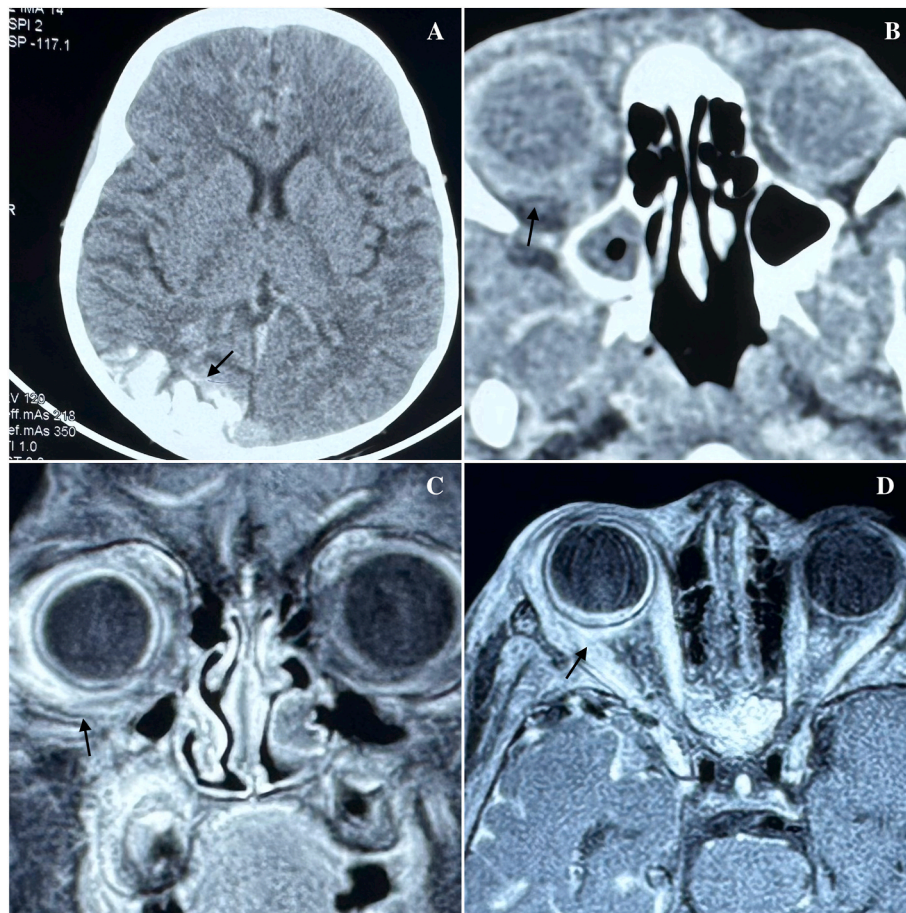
Computed tomography scan at presentation: A, Axial section of brain revealing cortical gyri-form calcifications in the right parieto-occipital lobe, indicated by the black arrow. B, Axial section of eye showing focal asymmetrical enlargement involving the posterolateral wall of the right eye ball (black arrow) with a thickened optic nerve head. C-D, Coronal and axial views, respectively, on Magnetic Resonance scan demonstrates diffuse thickening of the choroid of the right eye and corresponding enhancement of the choroid as indicated by the black arrow.
